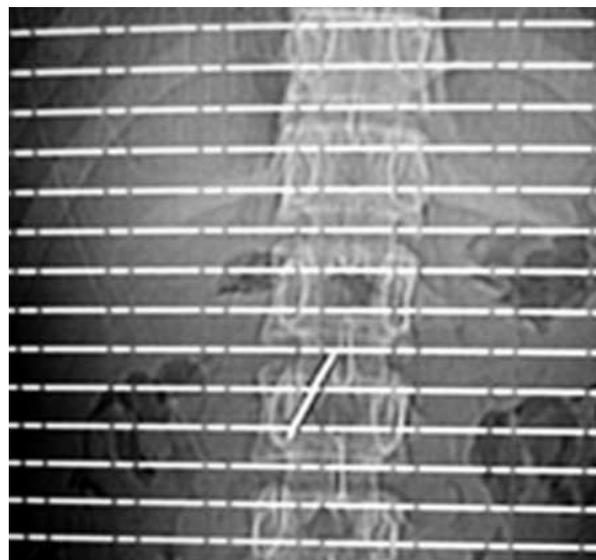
CT scanogram showing radio-opaque shadow suggesting needle.
